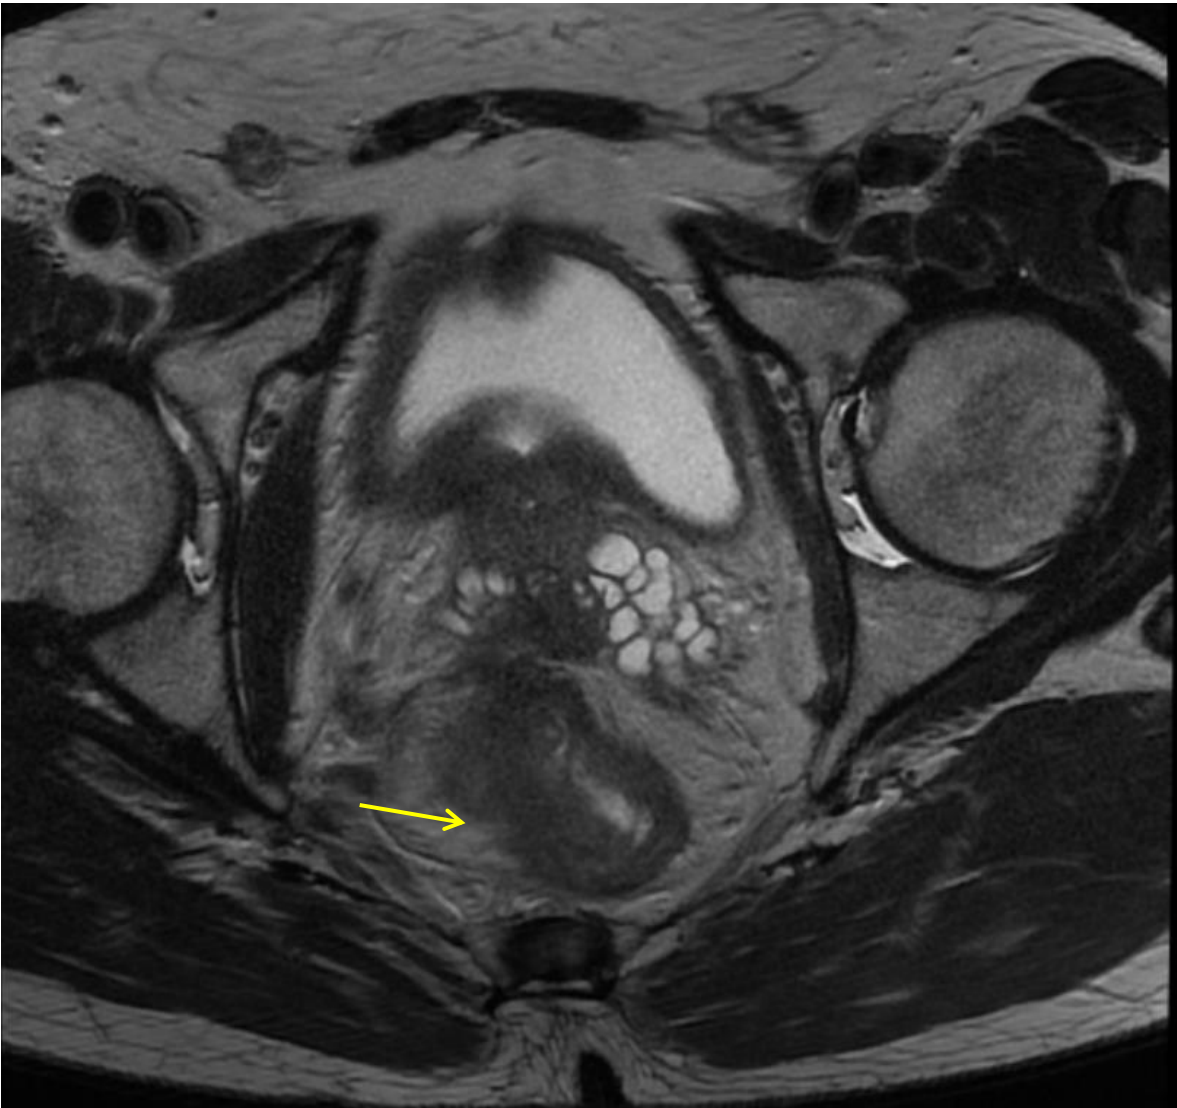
(Case 182) Coronal MRI images of a cT4bN1b rectal cancer in a 56-year old male patient, six centimetres from the distal margin, and with extensive infiltration of the mesorectal fascia (shown by the yellow arrows) and invasion of the prostate and the seminal vesicles.
